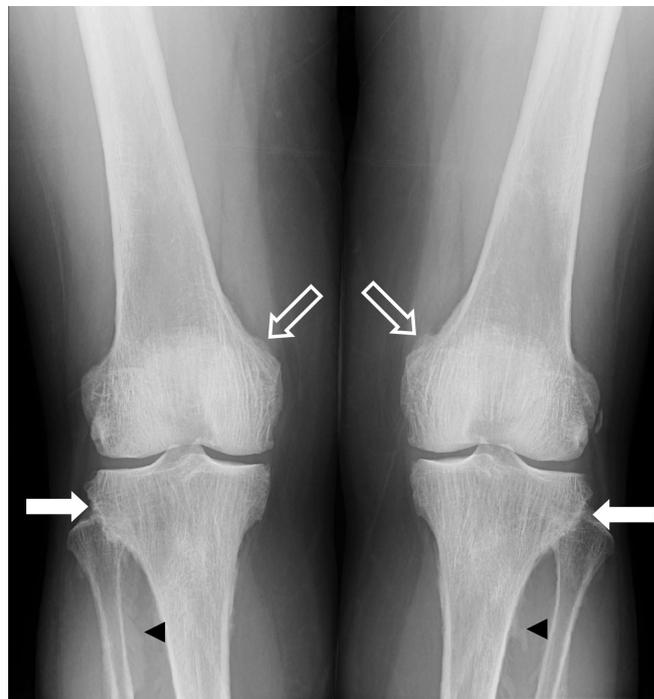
Anteroposterior weight-bearing radiograph of the knees is remarkable for thick, coarsened trabeculae clustered within cancellous bone of the distal femora, proximal tibiae, and proximal fibulae. Calcification and ossification affects the interosseous membranes (*black arrowheads*). Bony excrescences are present along the proximal lateral tibiae (*solid white arrows*) and medial femoral epicondyles at the site of muscular and ligamentous attachments (*hollow arrows*). There are no fractures, nor is there diaphyseal widening or bone deformity.
